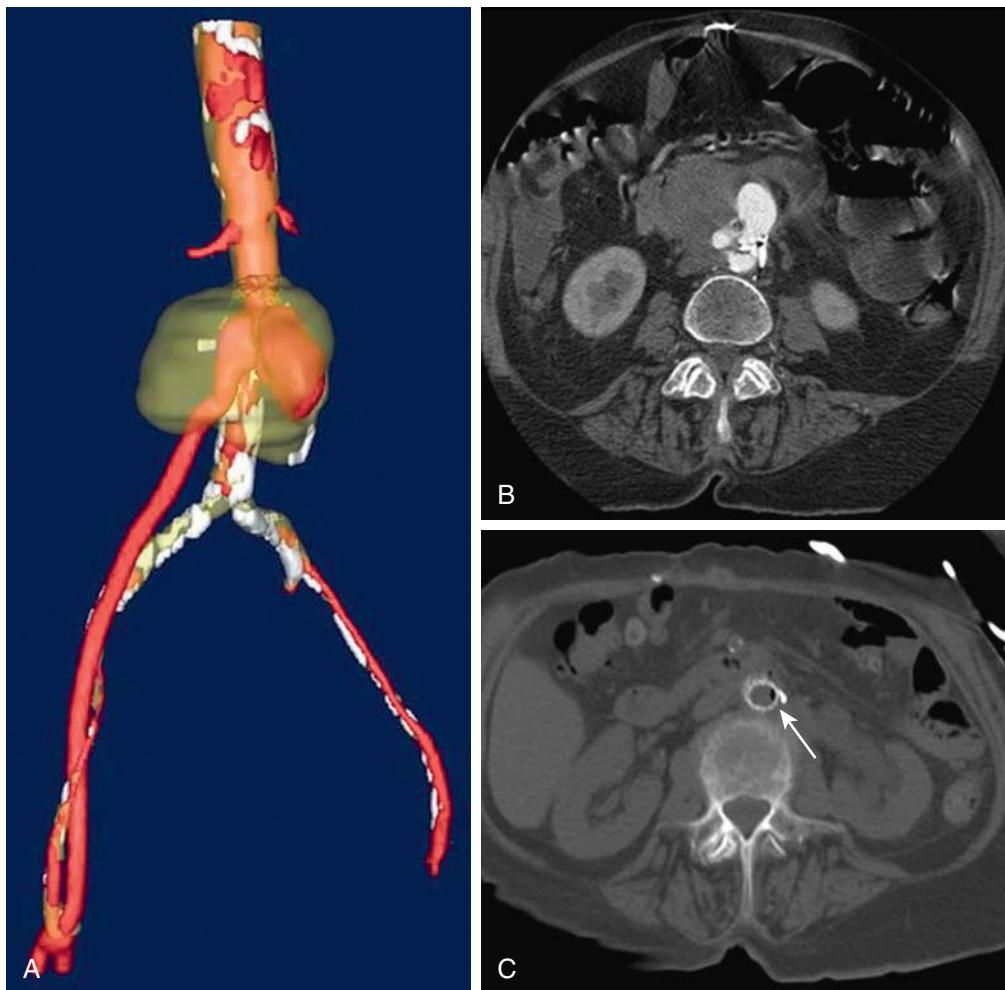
Three-dimensional reconstruction (A) and axial computed tomography imaging (B, C) of a proximal infected anastomotic pseudoaneurysm in an aortofemoral bypass graft. Arrow shows gas formed by infecting bacteria. (From Lew WK, et al. Endovascular management of mycotic aortic aneurysms and associated aortoenteric fistulas. *Ann Vasc Surg*. 2009;23:81–89.)
